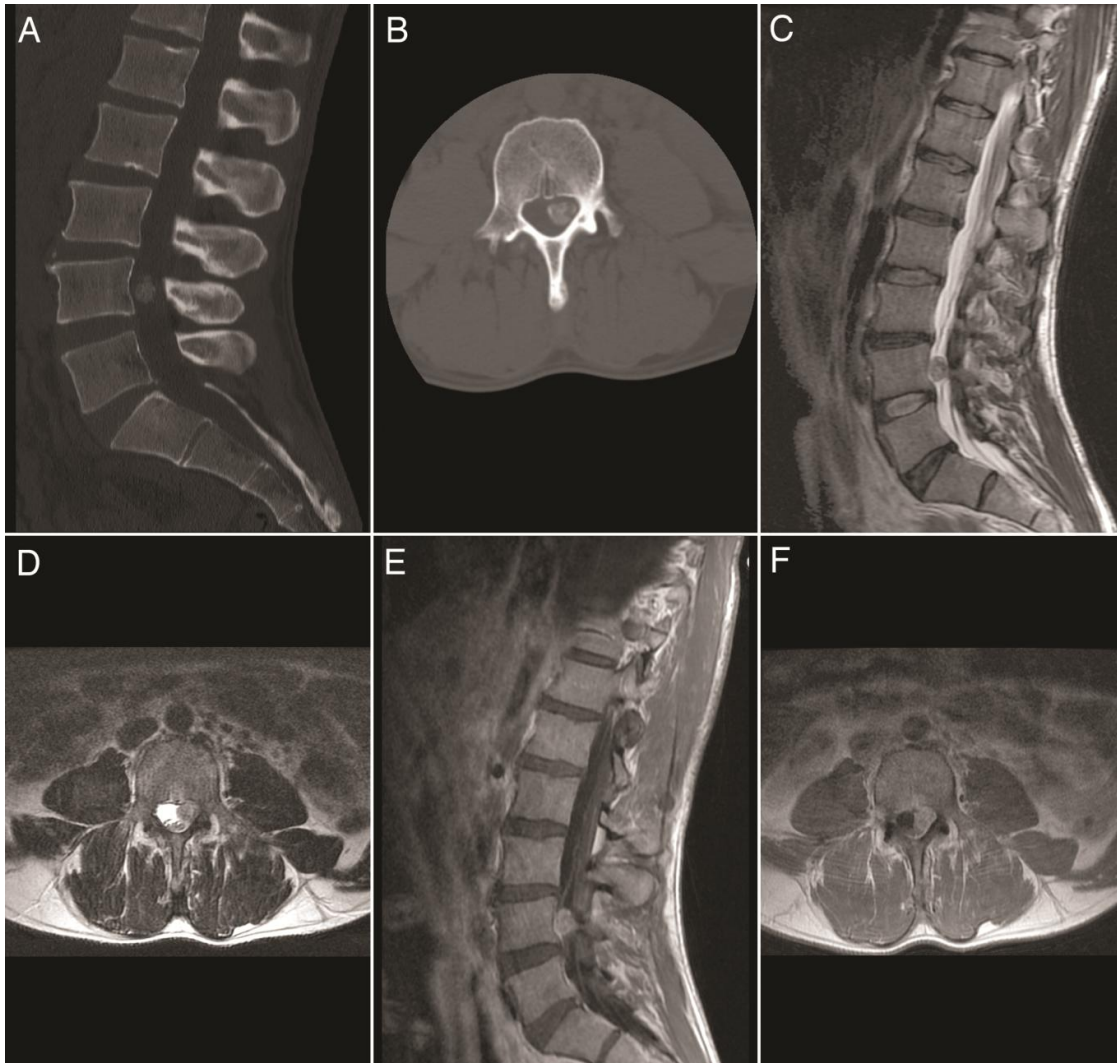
Sagittal (A) and axial (B) non-contrasted computed tomography (NCCT) showing a round, calcified mass in the central canal behind the L4 vertebral body without any bony changes. Sagittal T-2 weighted magnetic resonance imaging (MRI) showing a mass behind the L4 vertebral body with low signal attenuation (C). An axial T-2 weighted MRI showing a mass with low signal attenuation abutting the left L4 pedicle and compressing the existing L4 and the traversing L5 nerve roots (D). A gadolinium-enhanced sagittal MRI showing a nodular enhancing mass posterior to the L4 vertebral body (E). A gadolinium-enhanced axial MRI showing a mass in the central canal with nodular enhancement (F)
